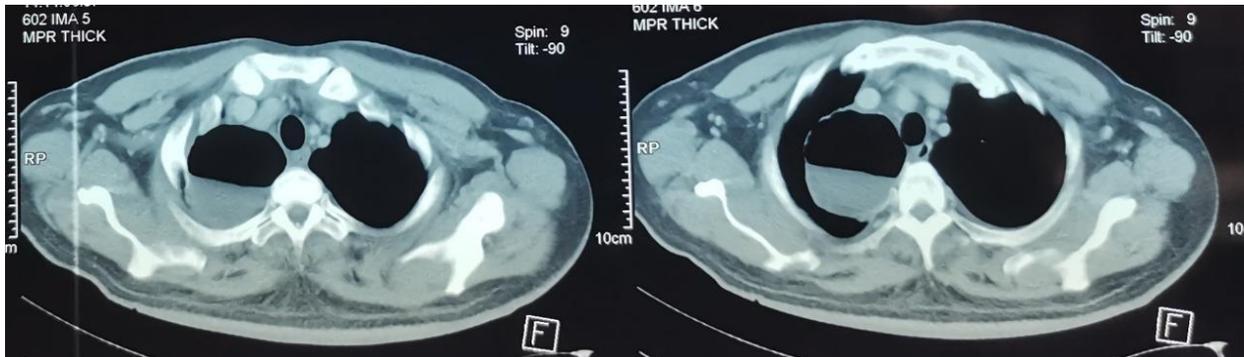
CT of the thorax shows a well-defined irregular thin-wall enhancing cavitating lesion with air-fluid level within (7.0×6.5×5.6 cm), seen at the apical segment of the right upper lobe.
